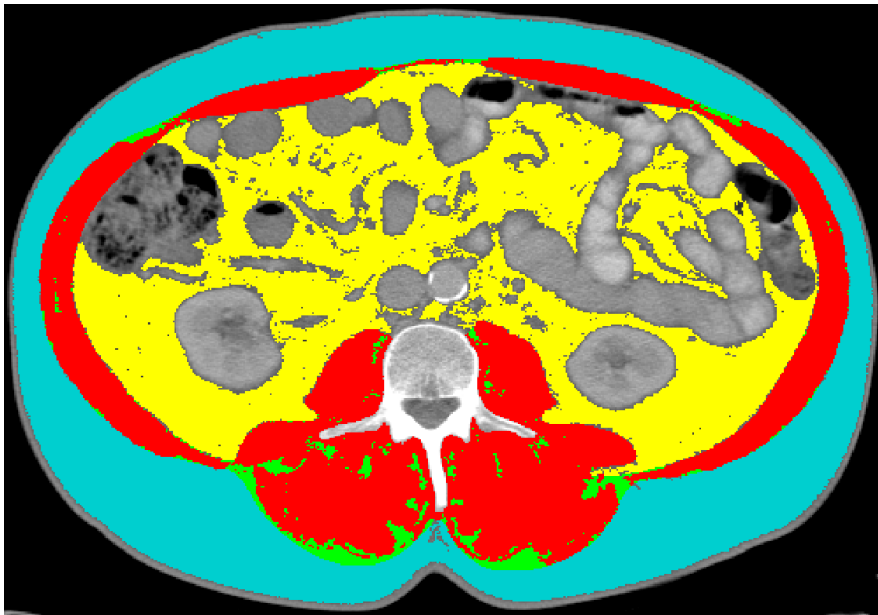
Segmented L3 CT cross sectional image. Red = Skeletal muscle, Blue = Subcutaneous adipose, Yellow = Visceral adipose, Green = Intermuscular adipose
